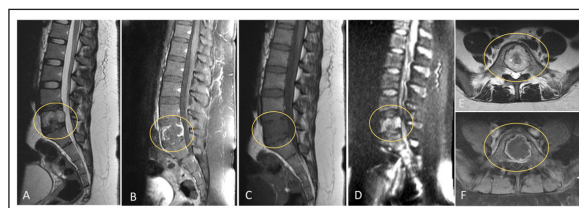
Preoperative images. Pre-operative magnetic resonance image MRI (A) sagittal T2, (B) T1 with contrast, (C) plain T1, (D) diffusion-weighted, (E) axial T2, (F) axial contrasted T1 showing a well defined lesion involving L5 vertebral body (yellow circle) with geographic sclerotic margin measuring 3x3.2x2 cm on AP, TR and CC dimensions with ring enhancement in T1 with contrast.
